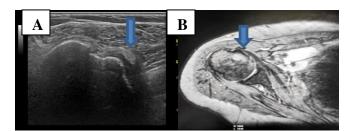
Female patient 60 years old complaining of biceps tendon subluxation from bicipital groove. (A) US: shows empty bicipital groove with echogenic tendon of long head of biceps muscle seen medial to lesser tuberosity; (B) MRI showed biceps tendon subluxation and empty bicipital groove. Case III
